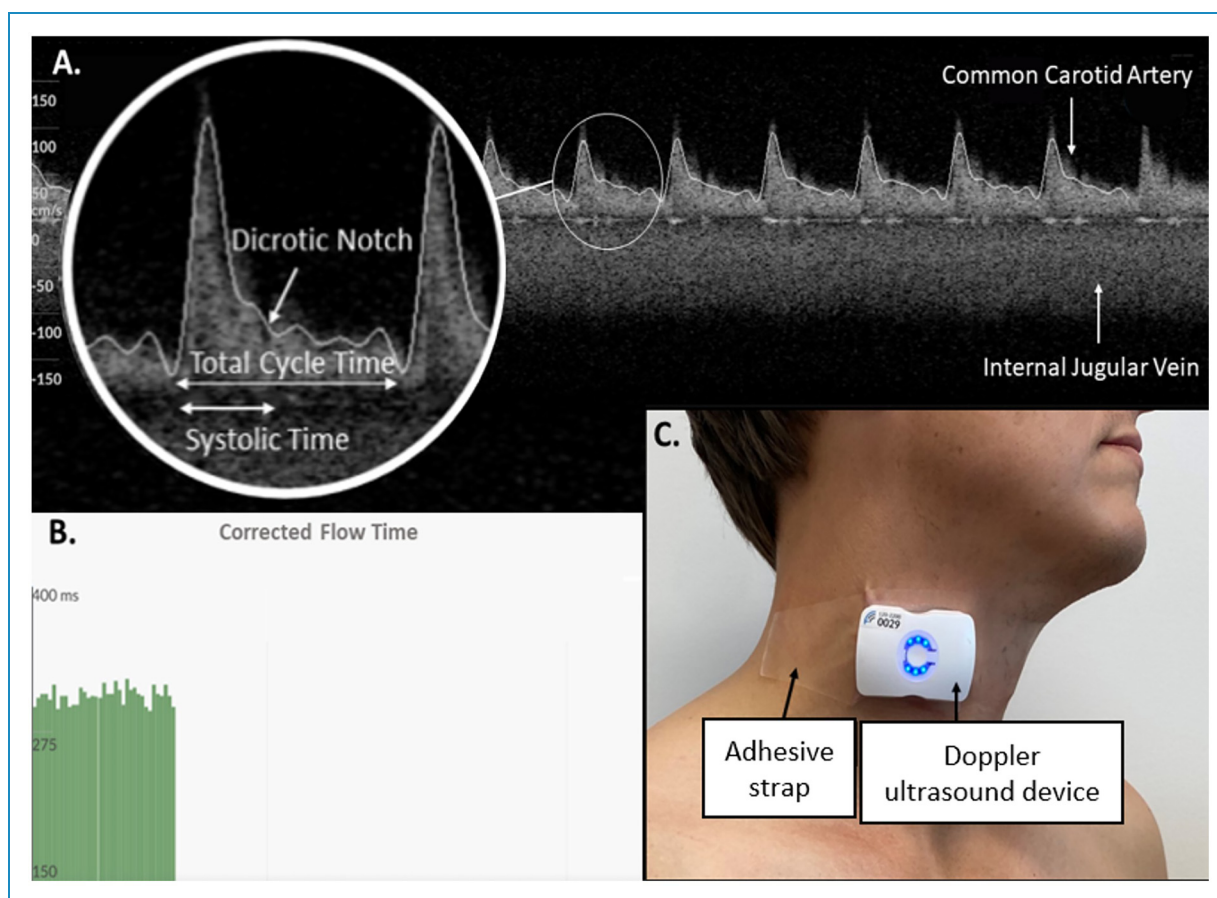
Overview of wearable Doppler ultrasound device and interface used for data collection. (a) Example of carotid Doppler spectrogram and features used to calculate ccFT values (inset) (b) ccFT values calculated per cardiac cycle on device interface. (c) The wearable Doppler device adhered to the neck of a sample patient.
